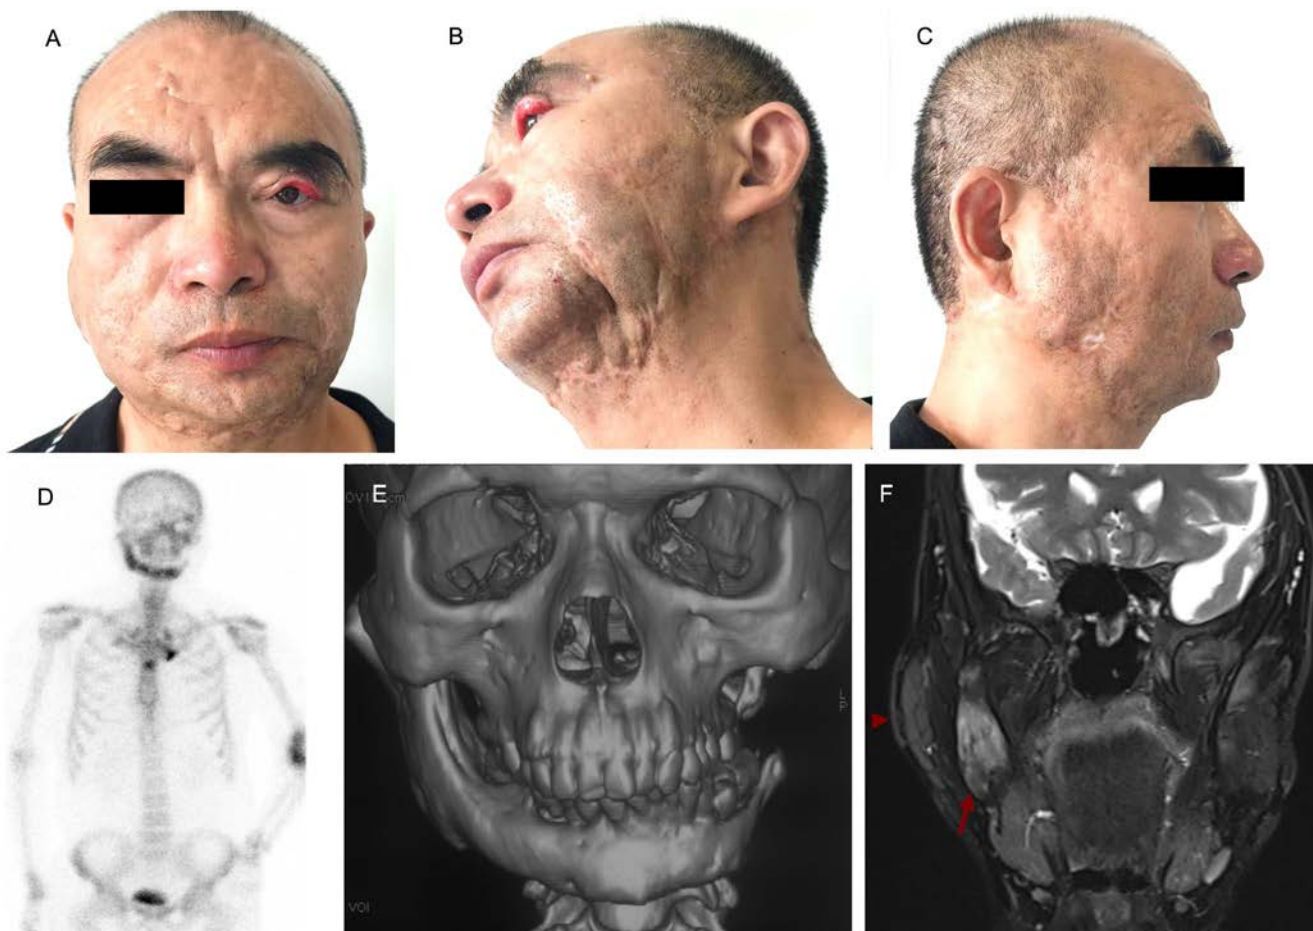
Mandibular osteolysis in a 48-year-old man with SAPHO syndrome. (A–C) Facial asymmetry due to mandibular osteolysis and extensive cutaneous and eyelid scarring (frontal, left, and right views). (D) Skeletal scintigraphy showing osteitis of the right mandible and alveolar bone, along with increased radionuclide uptake in the sternoxiphoid joint, left sternocostal joint, and left elbow. (E, F) CT and MRI revealing osteolysis of the left mandible, bone edema (arrow), and hyperostosis of the right mandible, and inflammatory thickening of the right subcutaneous tissue (arrowhead).
